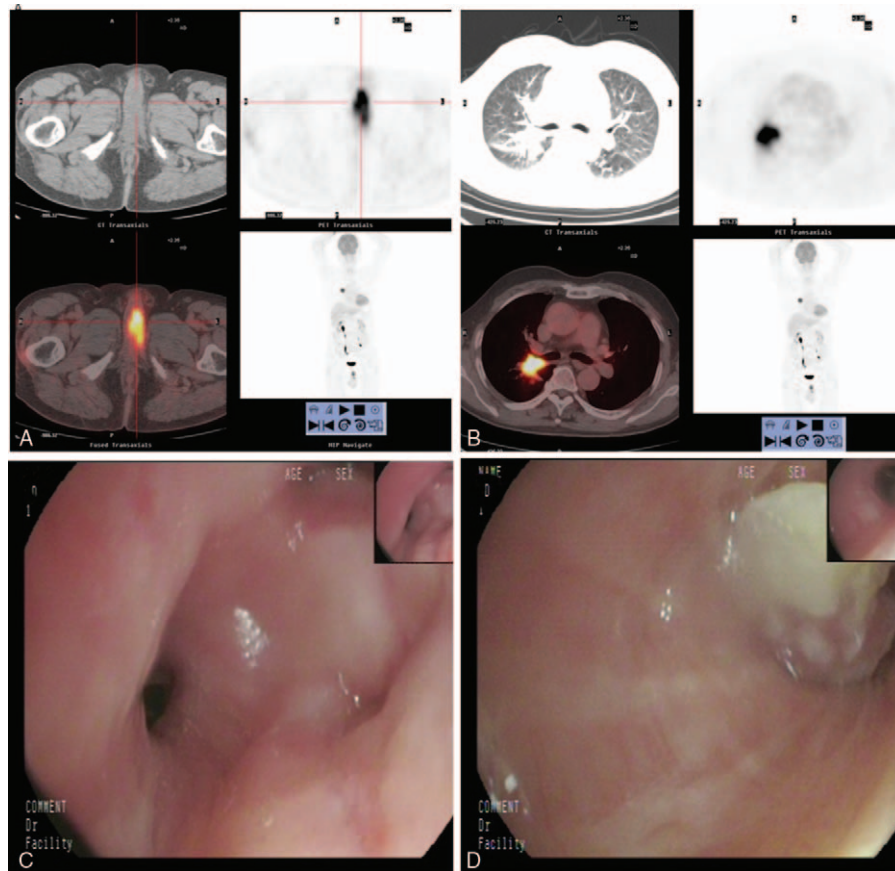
(A) Axial CT, PET-CT fusion, and PET images of pelvis demonstrate focus high uptake of 18F-fluorodeoxyglucose (FDG) in the base of left side corpora cavernosa; SUV_{max} of lesion is 12.0. (B) Axial CT, PET-CT fusion, and PET images of chest show a mass measured 3 cm \times 2 cm with uptake intense in the right hilar; SUV_{max} of lesion is 13.5. The posterior segmental bronchi of right upper lobe is obstructive. (C) Flexible bronchoscopy image shows stenosis of the opening of apical and posterior segmental bronchi of right upper lobe. (D) Flexible bronchoscopy image shows the lateral segmental bronchi of the left lower lobe obstructed by a neoplasm. CT=computed tomography, PET/CT= 18F-fluorodeoxyglucose positron emission tomography CT, FDG= 18F-fluorodeoxyglucose.
